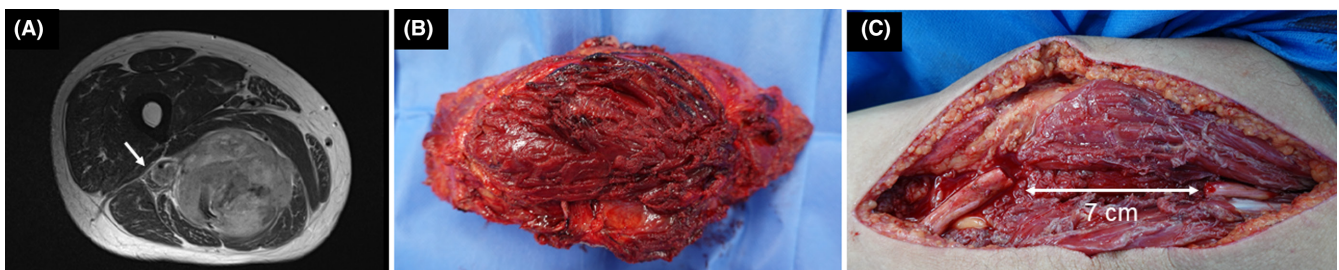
Preoperative T2-weighted magnetic resonance imaging of the right thigh revealing a huge soft tissue tumor, involving the sciatic nerve (arrow) (A). Plain photographs after the wide resection of the tumor and sciatic nerve (B) showing 7 cm of sciatic nerve defect (C).
